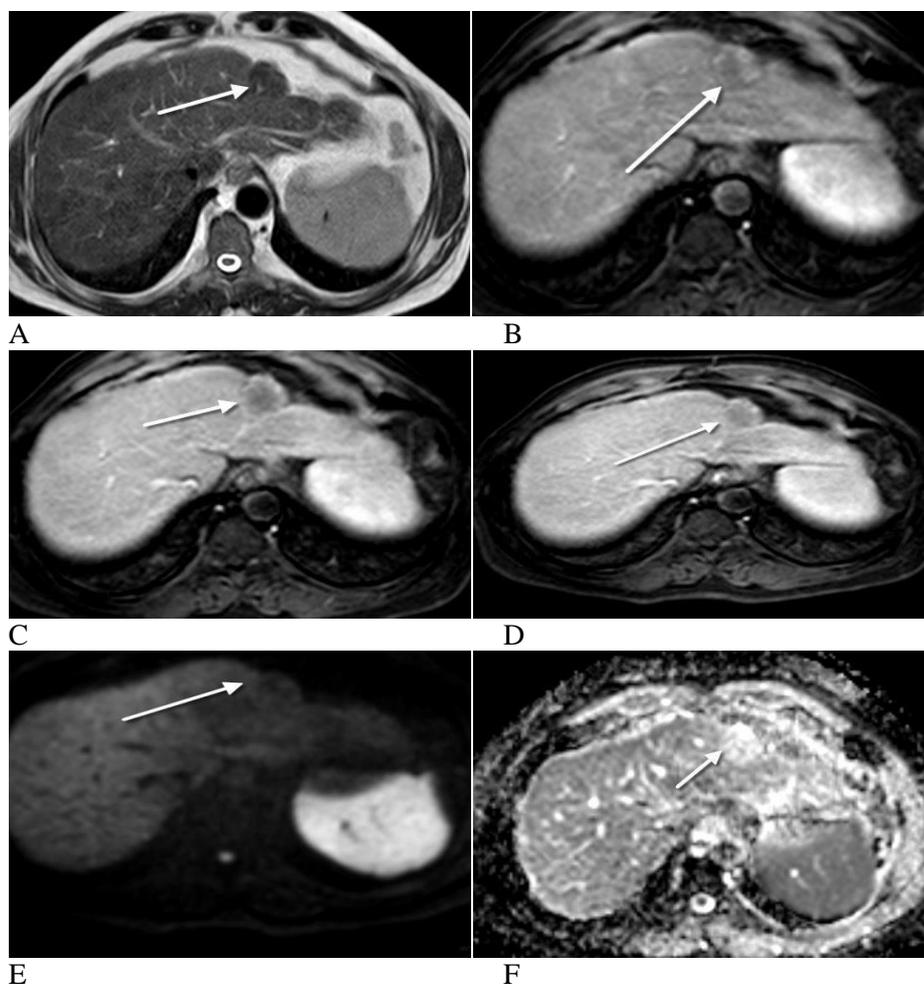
MRI of the liver showing Well ablated hepato cellular carcinoma.
